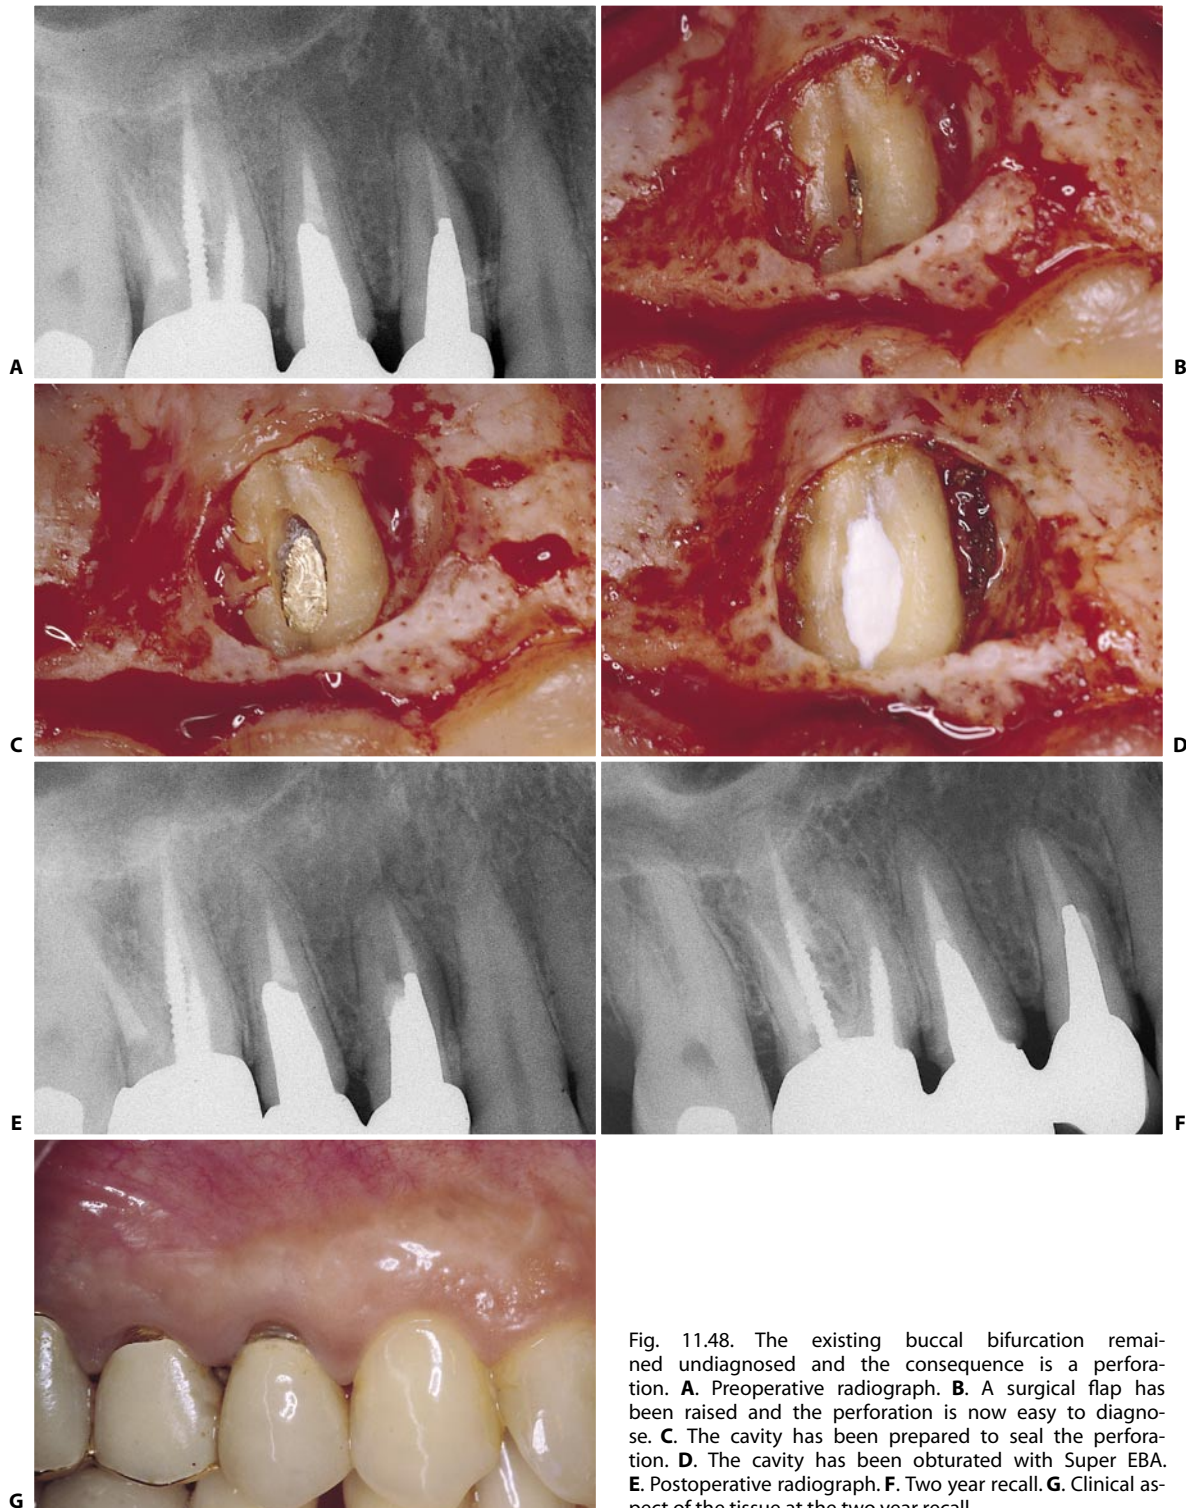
The existing buccal bifurcation remained undiagnosed and the consequence is a perforation. A. Preoperative radiograph. B. A surgical flap has been raised and the perforation is now easy to diagnose. C. The cavity has been prepared to seal the perforation. D. The cavity has been obturated with Super EBA. E. Postoperative radiograph. F. Two year recall. G. Clinical aspect of the tissue at the two year recall.
